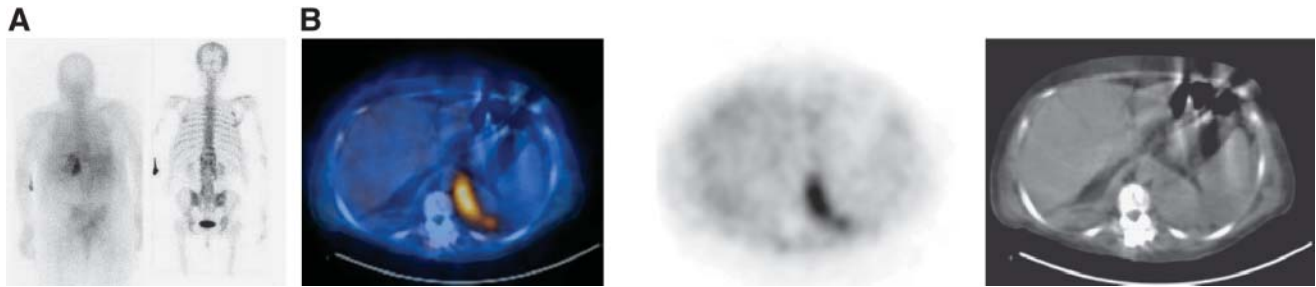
SPECT/CT for suspected bone infection on GS. A 56-y-old woman presented with fever, low back pain, and infected scar 1 mo after spinal surgery and was referred for GS for suspected vertebral osteomyelitis. (A) Planar posterior whole-body GS image (left) shows prominent abnormal uptake in left lower back, corresponding in part to regions of increased irregular uptake seen on planar posterior whole-body ^{99m}Tc -MDP image (right) along operated vertebrae. (B) Transaxial GS SPECT/CT image (left) localizes abnormal uptake on GS (center) to paravertebral soft-tissue abscess seen on corresponding CT image (right), thus defining soft-tissue infection without osteomyelitis. There was no evidence of vertebral osteomyelitis on follow-up CT 4 wk later.
